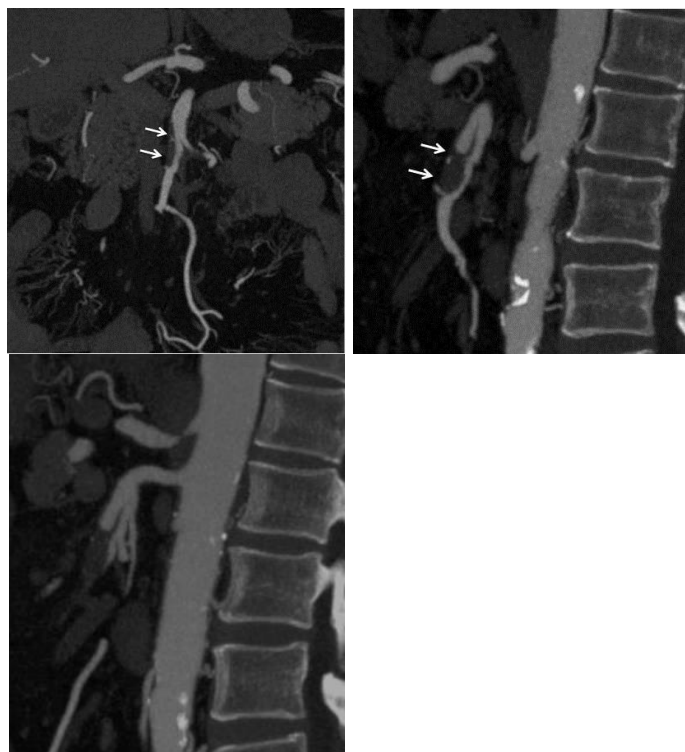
A 52-year-old man with abdominal pain. On coronal (a) and sagittal (b) MIP reconstruction CTA images, an isolated SMA dissection and thrombosis of false lumen (Type IIb) are observed (arrows). After 10 months, follow up CTA (c) was performed, which showed no significant difference in dissection (arrows).
